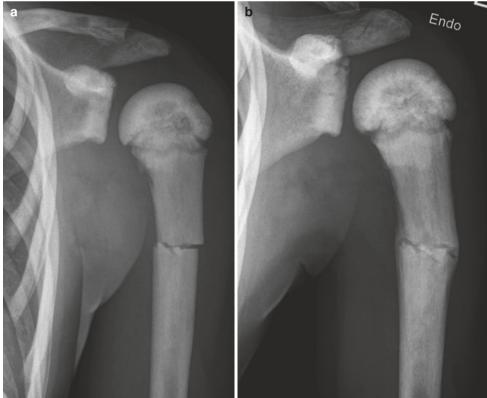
(a) Ten-year-old child who presented with pain after a fall. Radiograph shows a transverse fracture in dense sclerotic bone. (b) Radiograph after 10 weeks shows a healing fracture. There was a strong familial history of osteopetrosis but parents did not pursue genetic testing
